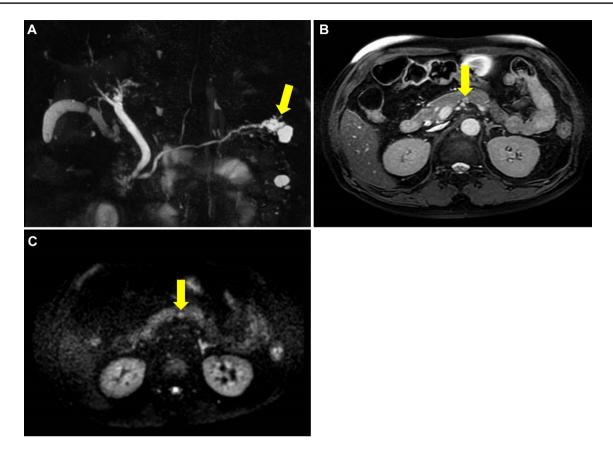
a Magnetic resonance cholangiopancreatography (MRCP) showed a branch duct-type IPMN (17 mm) in the tail of the pancreas (arrow) with no evidence of an increase in size from previous images. b Magnetic resonance imaging (MRI) T2-weighted image showed a
